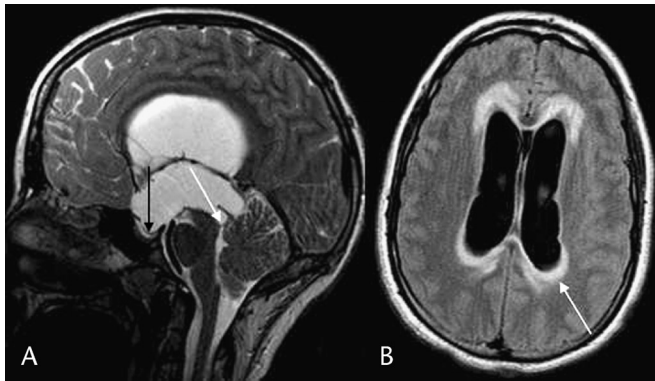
Hydrocephalus due to aqueductal stenosis. A, Sagittal T2 image demonstrates the aqueductal web (white arrow), small fourth ventricle, and marked third ventricular enlargement with ballooning of the anterior and posterior recesses plus downward displacement of the floor into the sella (black arrow). B, Axial FLAIR image shows the markedly dilated lateral ventricles with hyperintense periventricular edema (white arrow).
